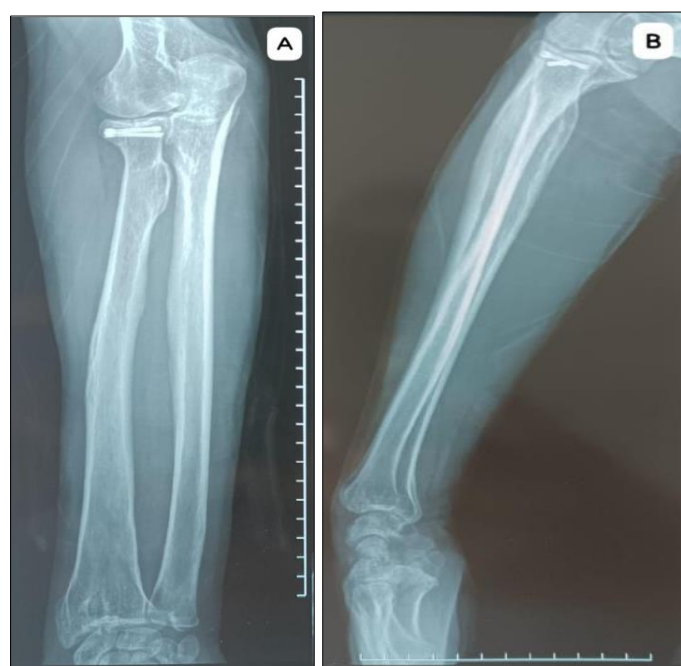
Last follow-up radiographic views of the distal radius and radial head showing uneventful bony union
